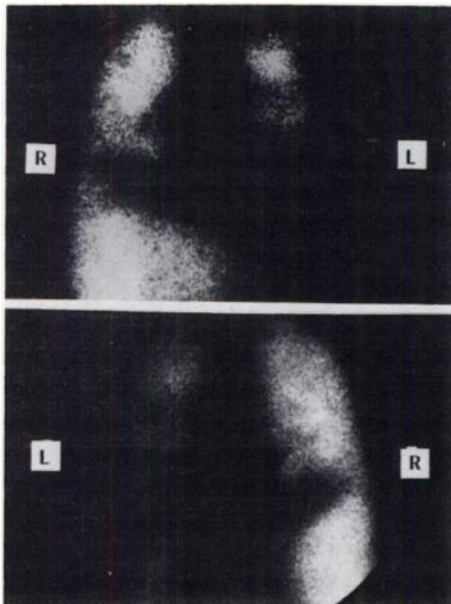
Liver-lung scintigrams, obtained with ^{99m}Tc -sulfur colloid followed by ^{99m}Tc -macroaggregated ferrous hydroxide, show defect between right lung base and liver. (A) Anterior view; (B) posterior view.
